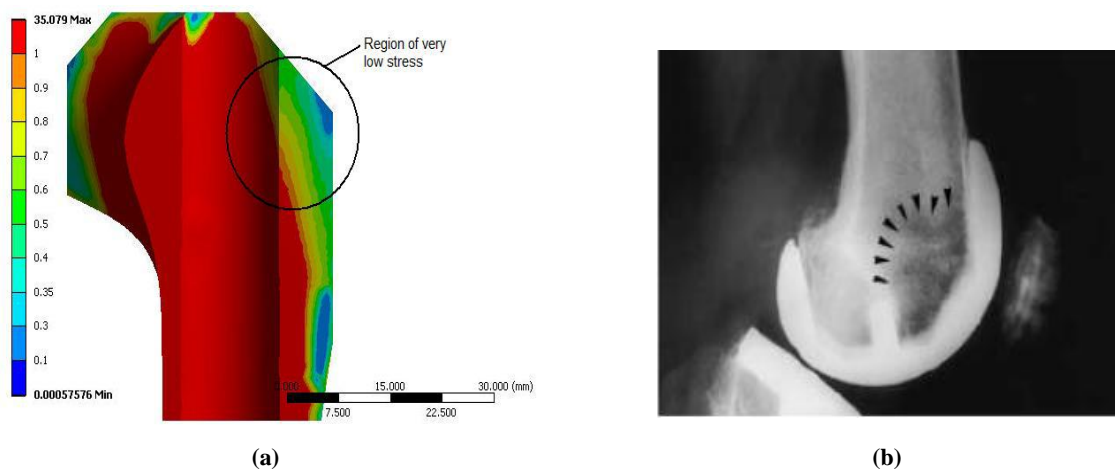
(a) Stress-shielded region in the anterior distal femur obtained by Mahboob [40], (b) X-ray radiograph from van Loon et al. showing Stress-shielded region in the anterior distal femur [146].
